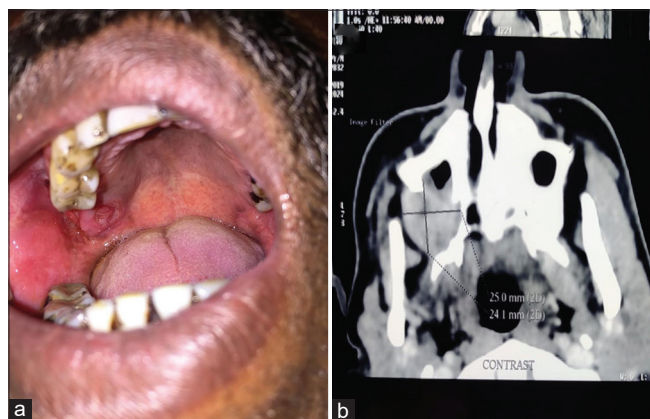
(a) Preoperative photo showing the primary lesion. (b) Axial section of contrast enhanced computed tomographic showing extension of the lesion
